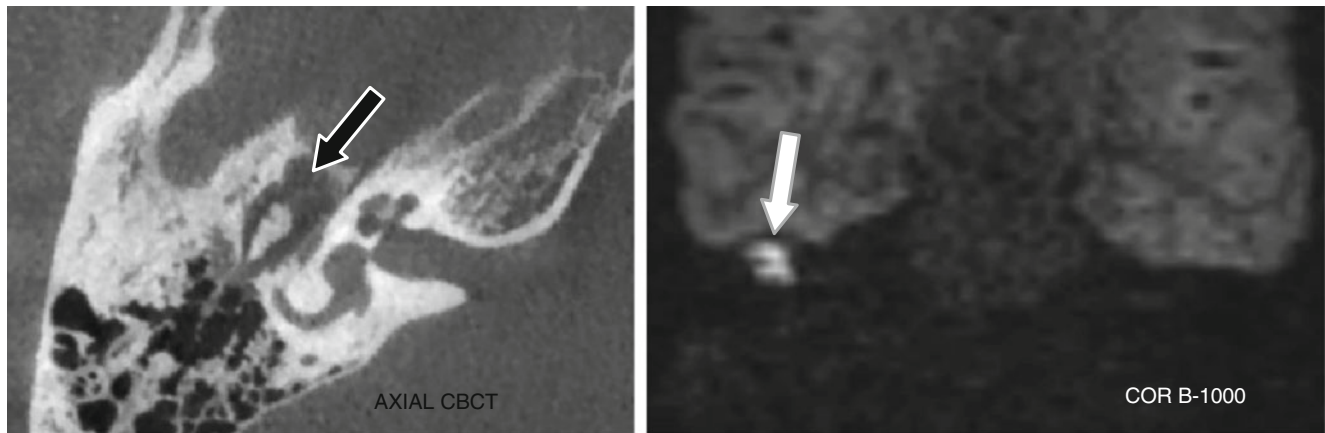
Axial CBCT showing a completely non-aerated middle ear; a cholesteatoma cannot be ruled out. A cholesteatoma can be seen on the B-1000 non-EPI DWI image (white arrow) and corresponded with the non-aerated region in the pro-epitympanum on CBCT (black arrow)
